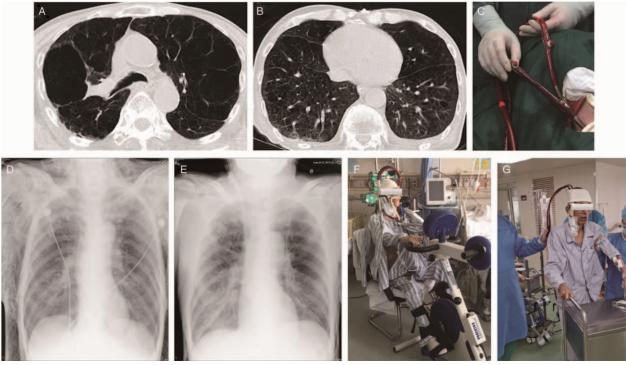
(A, B) Chest computed tomography before ECCO₂R of patient 1. (C) The procedure of ECCO₂R. (D) Extensive subcutaneous emphysema of patient 2 before ECCO₂R. (E) The barotrauma of patient 2 was effectively improved with the 9 days' treatment of ECCO₂R. (F) Treadmill exercise during ECCO₂R-assisted period. (G) Rehabilitation exercise during ECCO₂R-assisted period. ECCO₂R: Extracorporeal carbon dioxide removal.
